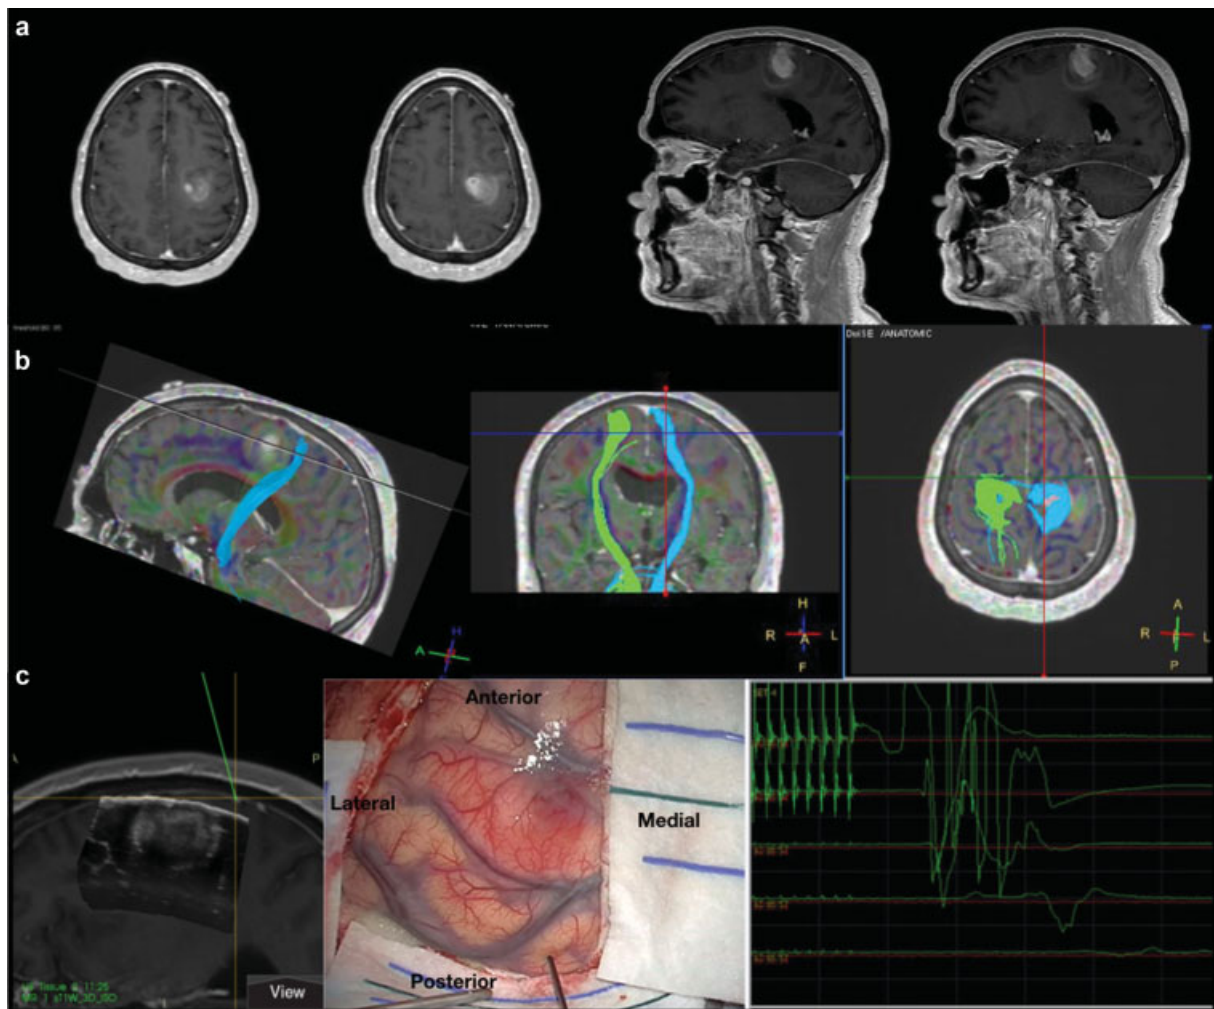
Patient no. 4. (a) Preoperative T1-weighted magnetic resonance imaging (MRI) with gadolinium showing a left posterior frontal glioblastoma (adjacent to the central sulcus). (b) Tractographic study of the same patient; the tumor displaces the corticospinal tract slightly posteriorly and medially. (c) From left to right: intraoperative ultrasound (iUS) superimposed to the corresponding preoperative MRI; the *yellow crosshair* identifies the position of the stimulating probe; intraoperative picture: the stimulating probe is placed posterior to the tumor. Positive mapping confirming the position of motor area with respect to the tumor. The anterior and lateral margins of the tumor result relatively far from the motor pathway.
